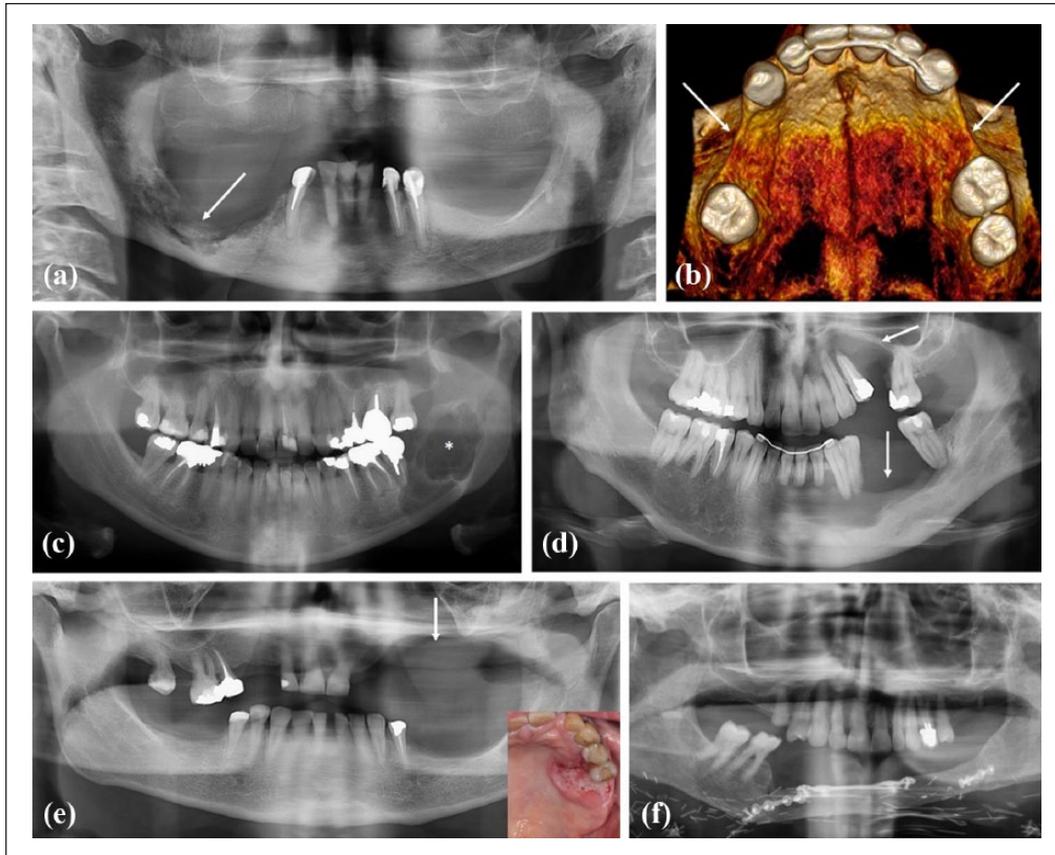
Various origins of bone defects: (a) Panoramic X-ray. Bone defect of the mandible right body corresponding to an osteonecrosis of the jaw in relation to denosumab taking. (b) 3D-reconstructed view of upper jaw. Bilateral bone defect of premolar regions associated to tooth agenesis in a young adult presenting a WNT10A gene mutation. (c) Panoramic X-ray. Bone defect (radiolucency, *) of the mandible right ramus corresponding to an ameloblastoma, an odontogenic aggressive benign tumor. (d) Panoramic X-ray. Bone defect (radiolucency, arrows) of upper and lower jaws corresponding to a trauma. (e) Panoramic X-ray. Bone defect (arrow) of upper jaw after resection surgery of a gingival squamous cell carcinoma (clinical view, left corner). (f) Reconstruction of the mandible by autogenous bone (fibula) following an invasive squamous cell carcinoma of the gingiva.
